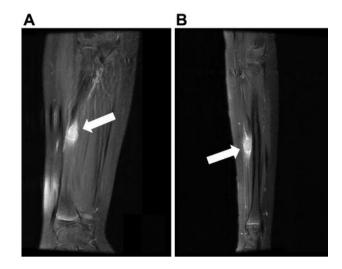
Melanoma metastases in the soft tissues of the (A) thigh and (B) forearm, visualized in the MRI.
